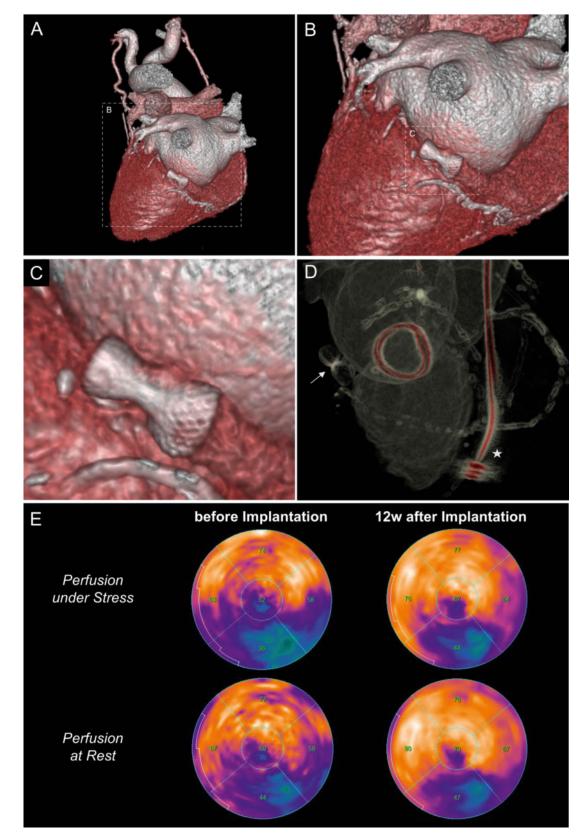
Coronary computed tomography angiography-derived 3D reconstruction of the Reducer[™] in position and comparison of myocardial perfusion before and after implantation as assessed by ¹³N-NH₃ positron emission tomography–myocardial perfusion imaging (PET-MPI). (A–D) The Reducer[™] has an hour glass-like shape and is implanted deep in the coronary sinus (arrow). 3D reconstruction demonstrates the position in relationship to the implanted mitral valve ring (arrow heads) and pacemaker electrode (star). (E) Compared with the status before implantation, perfusion both at rest and under stress is considerably increased by the Reducer[™] (yellow/orange: normal perfusion, purple: reduced perfusion).
